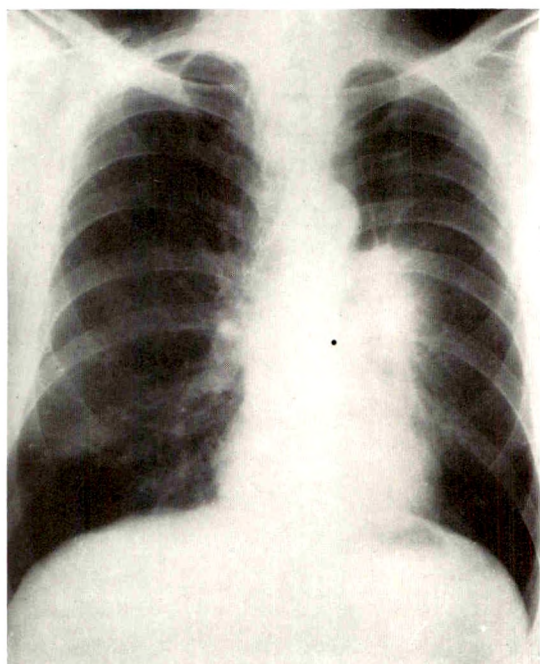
Case I. Posteroanterior chest roentgenogram (June 23, 1959) shows slight reduction in volume of the left hemithorax. A homogeneous density extends from the left hilus. The vascular markings are diminished throughout the left lung field. The main vascular shadows are reduced in size and number and are spread out.
